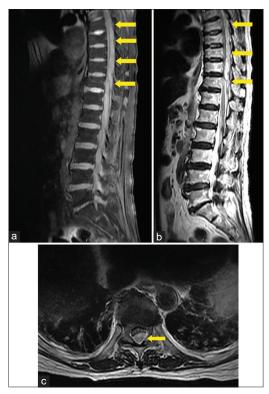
Magnetic resonance imaging of the lumbosacral spine. (a) T1-weighted imaging sagittal view revealing an isointense lesion in the dorsal epidural space from T3–T11, (b) T2-weighted imaging sagittal view revealing the same hyperintense lesion, (c) T2-weighted imaging axial view revealing the hyperintense lesion occupying the spinal canal and compressing the spinal cord
